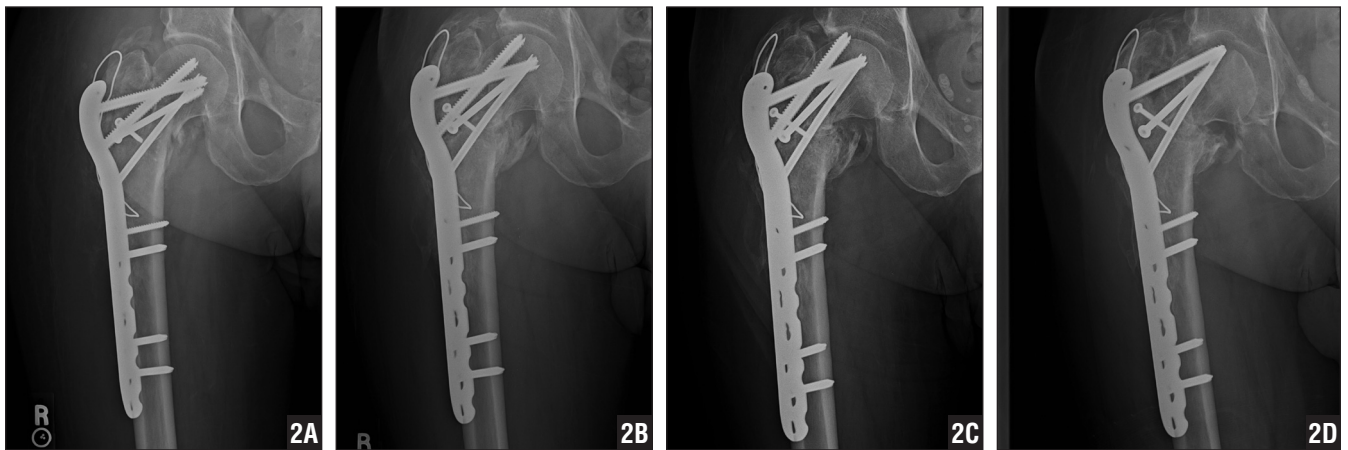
Patient 11. Postoperative anteroposterior radiographs at 2 months showing the plate construct (A), at 4 months showing the beginning of varus collapse (B), at 6 months showing continued collapse and screw penetration into the joint (C), and at 19 months showing continued collapse after screw removal (D).
